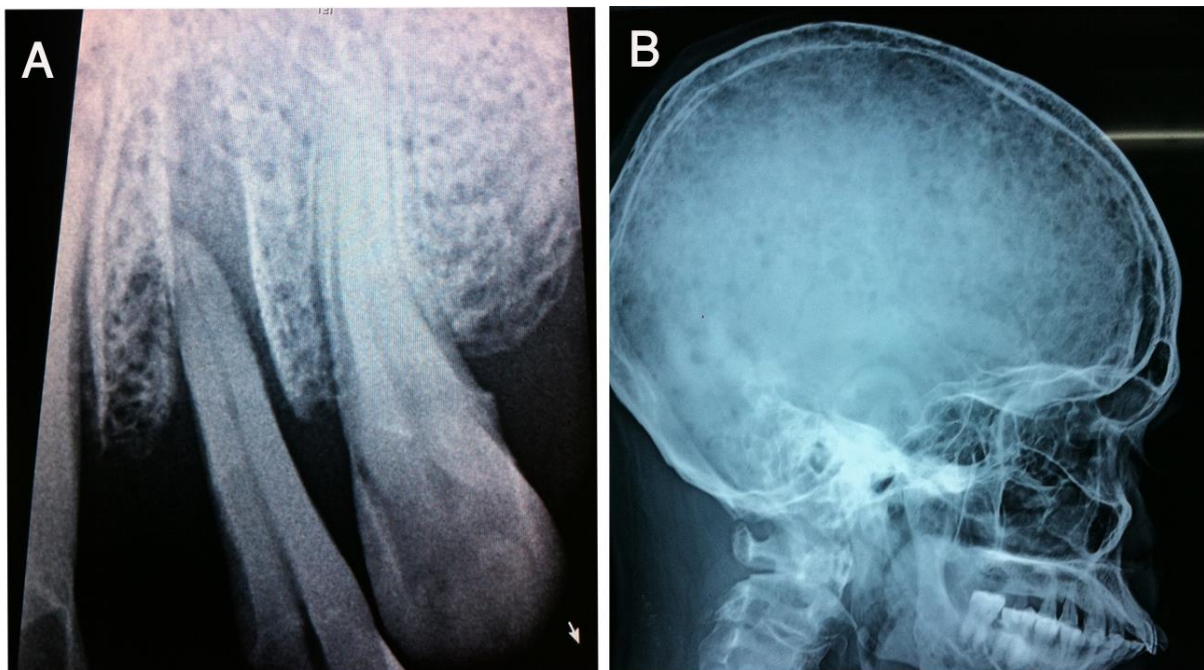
A) X-ray shows mobility of teeth; B) Pepper spotted appearance in skull
